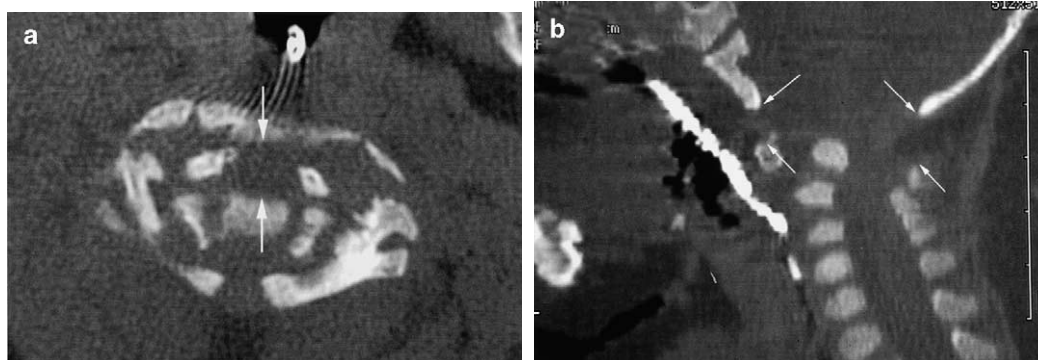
(a) Axial CT scan through the ring of C1 shows disruption of the Osseo cartilaginous ring and marked widening of the atlantodental interval (arrows). (b) Sagittal CT reformat through the occipitocervical region reveals atlantoaxial subluxation and narrowing of the space available for the cord. Widening between the occiput and C1-2 complex is also demonstrated (arrows).
